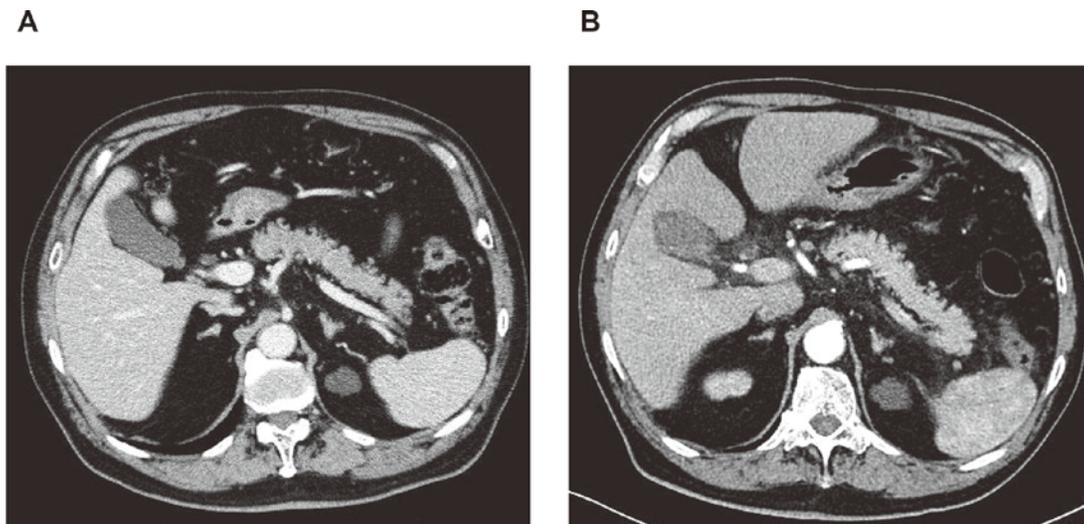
Computed tomography of the abdomen demonstrated an irregular outline of the pancreas and a peripancreatic fluid collection (before [A] and after [B] transhepatic arterial infusion).
